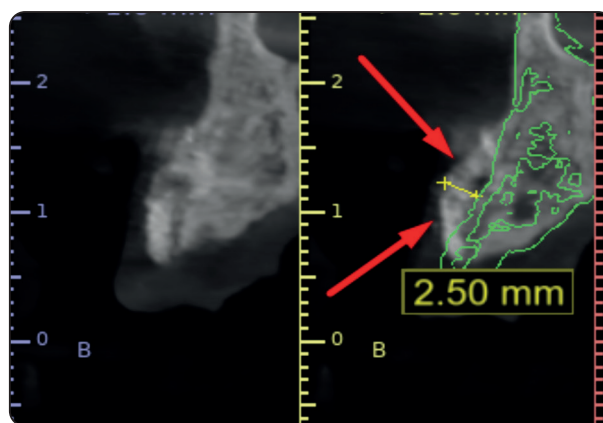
Photo-radiograph showing Preoperative CBCT was superimposed on 6 months postoperative CBCT.
